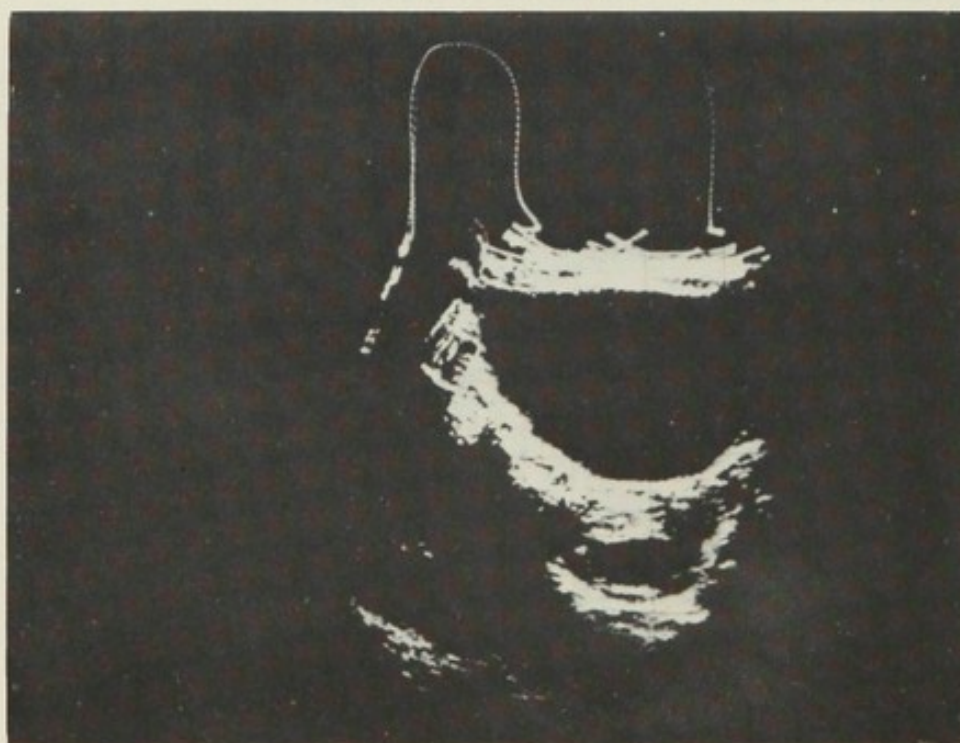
Blighted ovum at eleven weeks' gestation. Fifth pregnancy with no living children. Cervical cerclage a week previously. (Aborted again spontaneously three days after ultrasonography, which should have preceded cerclage.)
